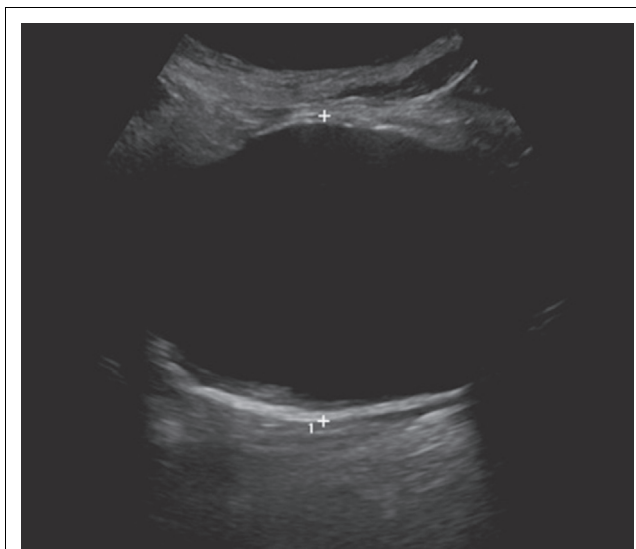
Transverse view B mode ultrasound image of abdominal aortic aneurysm, with white callipers demonstrating the outer wall to outer wall anteroposterior diameter measurement.
